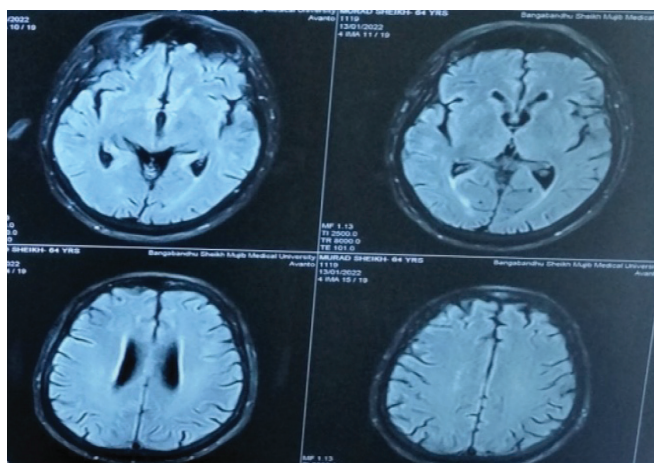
MRI of the brain(T2 FLAIR) showing hyperintense signal change at the left parietal region
